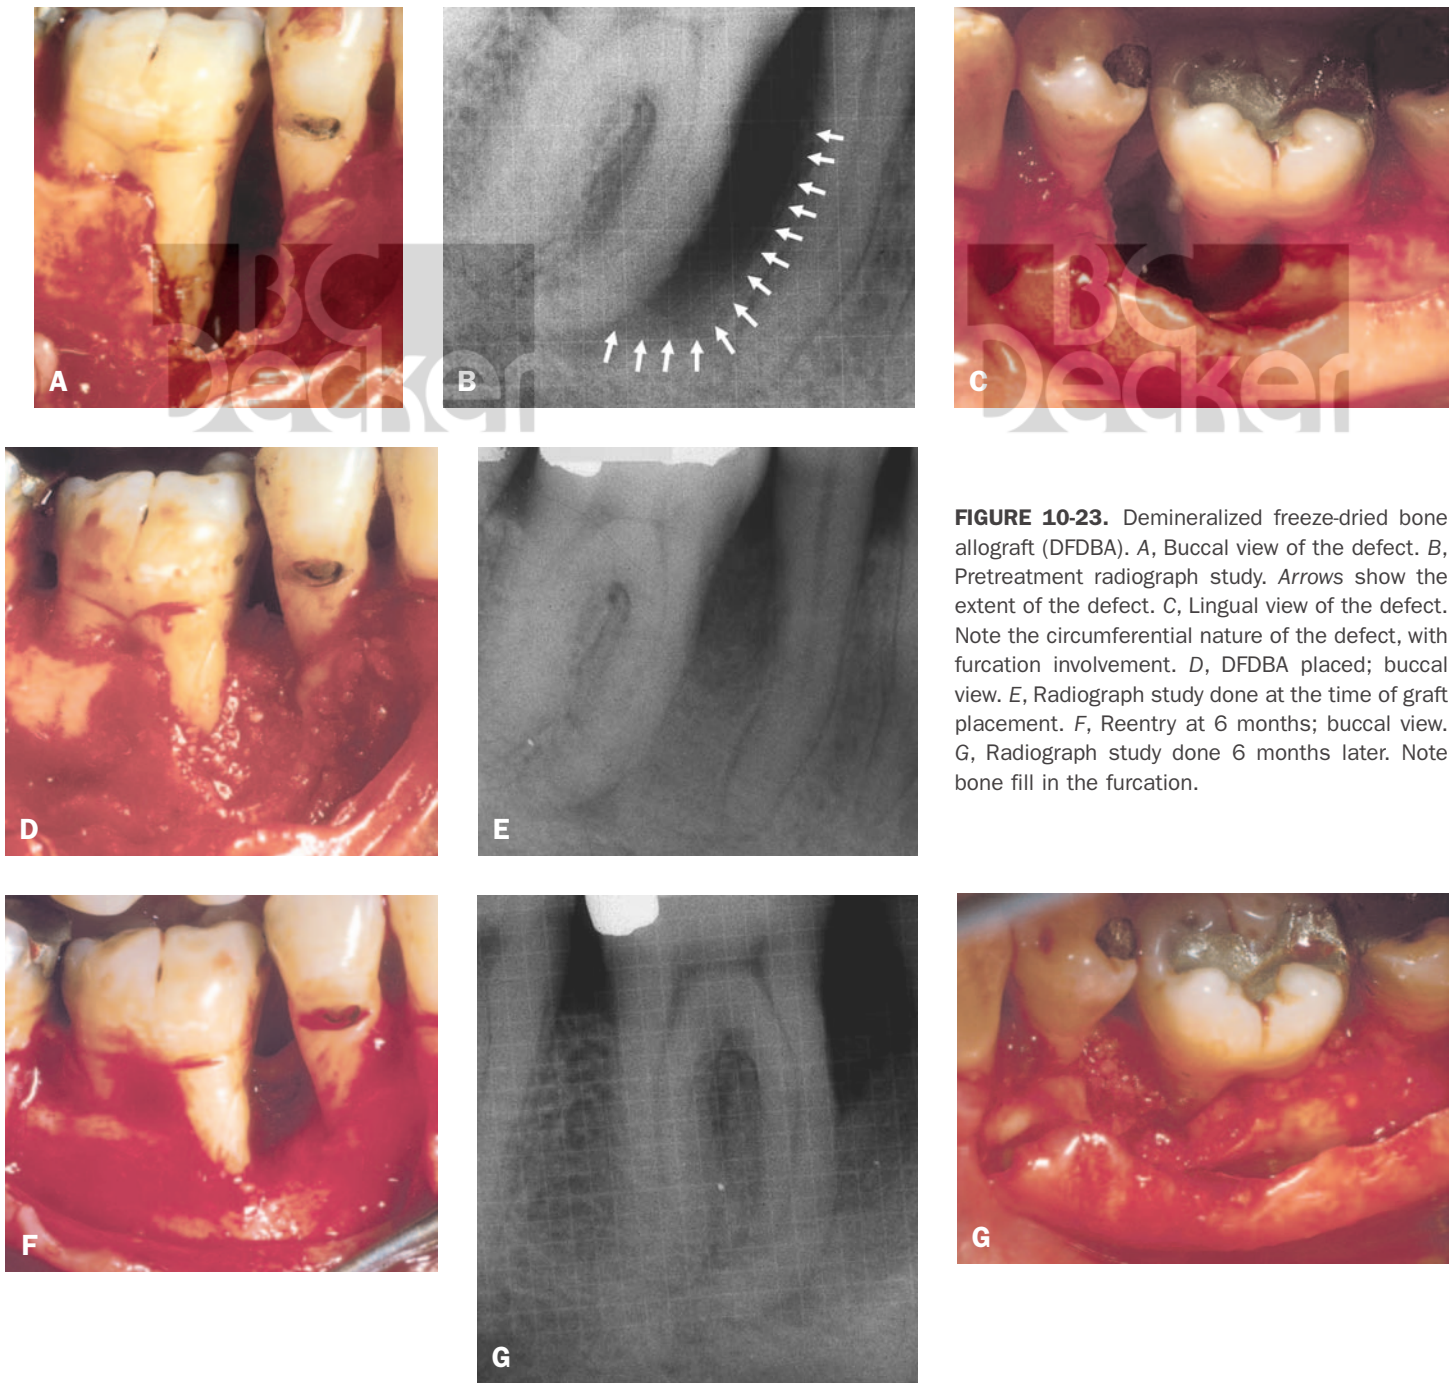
Demineralized freeze-dried bone allograft (DFDBA). *A*, Buccal view of the defect. *B*, Pretreatment radiograph study. Arrows show the extent of the defect. *C*, Lingual view of the defect. Note the circumferential nature of the defect, with furcation involvement. *D*, DFDBA placed; buccal view. *E*, Radiograph study done at the time of graft placement. *F*, Reentry at 6 months; buccal view. *G*, Radiograph study done 6 months later. Note bone fill in the furcation.
